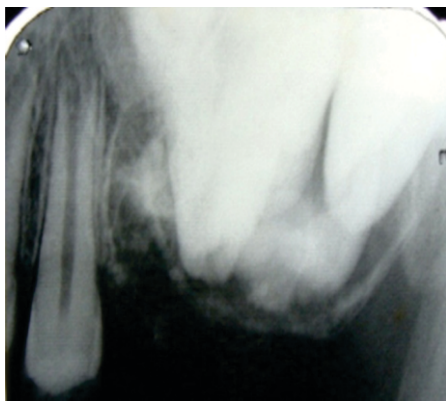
Peri Apical Radiograph Showing Impacted First, Second Molars and Tooth Crypt of Third Molar with Multiple Radiopacities on the Occlusal Surfaces
